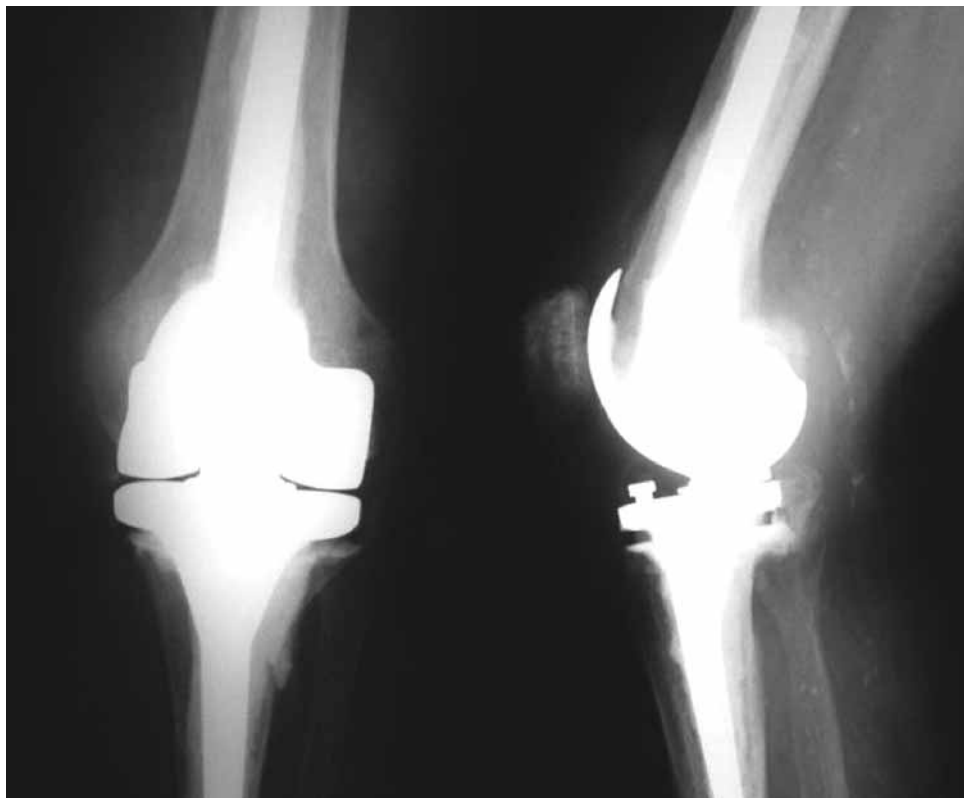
Postoperative radiograph demonstrating Waldemar Link Rotating Hinge TKR
